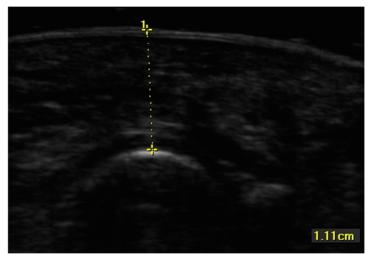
Measurement of the plantar soft-tissue thickness under the 3rd MTP joint, using ultrasound B mode image.
